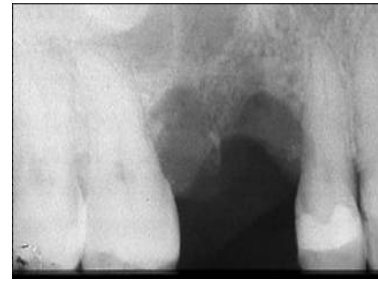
The radiography shows the bone defect
